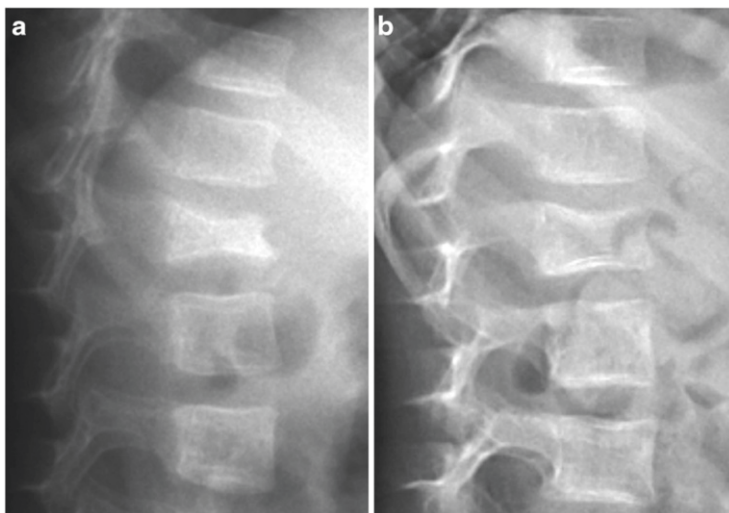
Improvements in axial skeleton following bisphosphonate treatment. Lateral thoracolumbar spine radiograph showing vertebral crush fracture of L1 in a 3-year-old with osteogenesis imperfecta (a). Improvements in vertebral morphology were evident following 2 years of bisphosphonate therapy (b)
